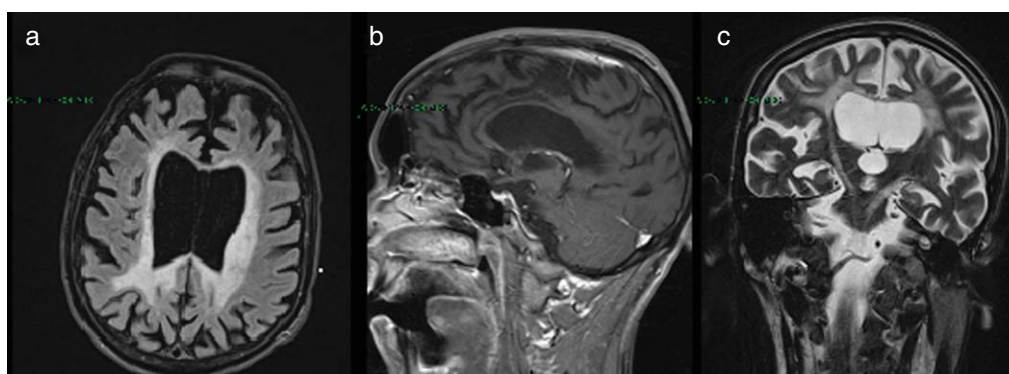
MRI: Neuroimaging of the patient. a) Fluid attenuated inversion recovery axial magnetic resonance image (MRI) shows brain atrophy, ventriculomegaly, and symmetrical hyperintensity of the periventricular white matter, with predominant parieto-occipital involvement. Subcortical U-fibers are relatively spared. b) T1-weighted sagittal MRI shows brain atrophy and severe thinning of the corpus callosum. c) T2-weighted coronal MRI shows a hyperintense signal in the pyramidal tracts.
